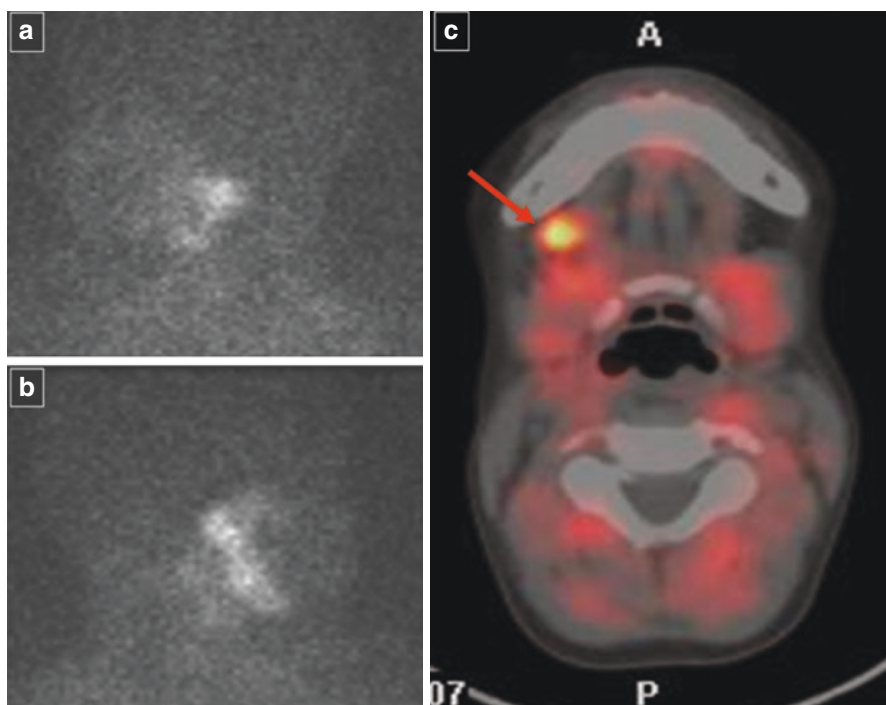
Pictorial example of a patient with recurrent NB showing no pathological uptake in the ^{123}I -MIBG scintigraphy (a, b lateral views of the head); the same patient investigated with ^{18}F -DOPA PET/CT documented clear submandibular right node metastases (c, fused axial view; red arrow)
